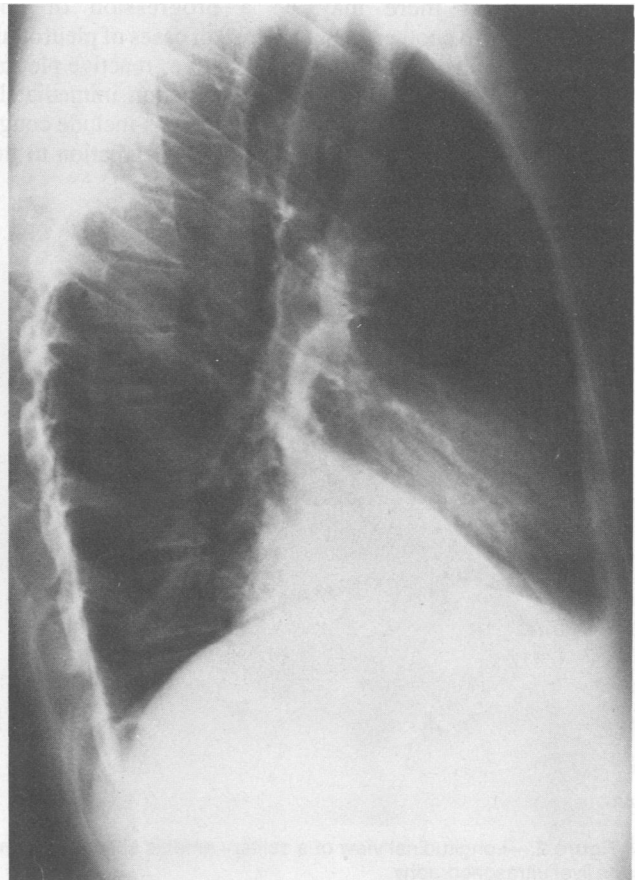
Radiographs of the chest showing left lower lobe infiltrate with consolidation. Left, anteroposterior view; right, lateral view.
